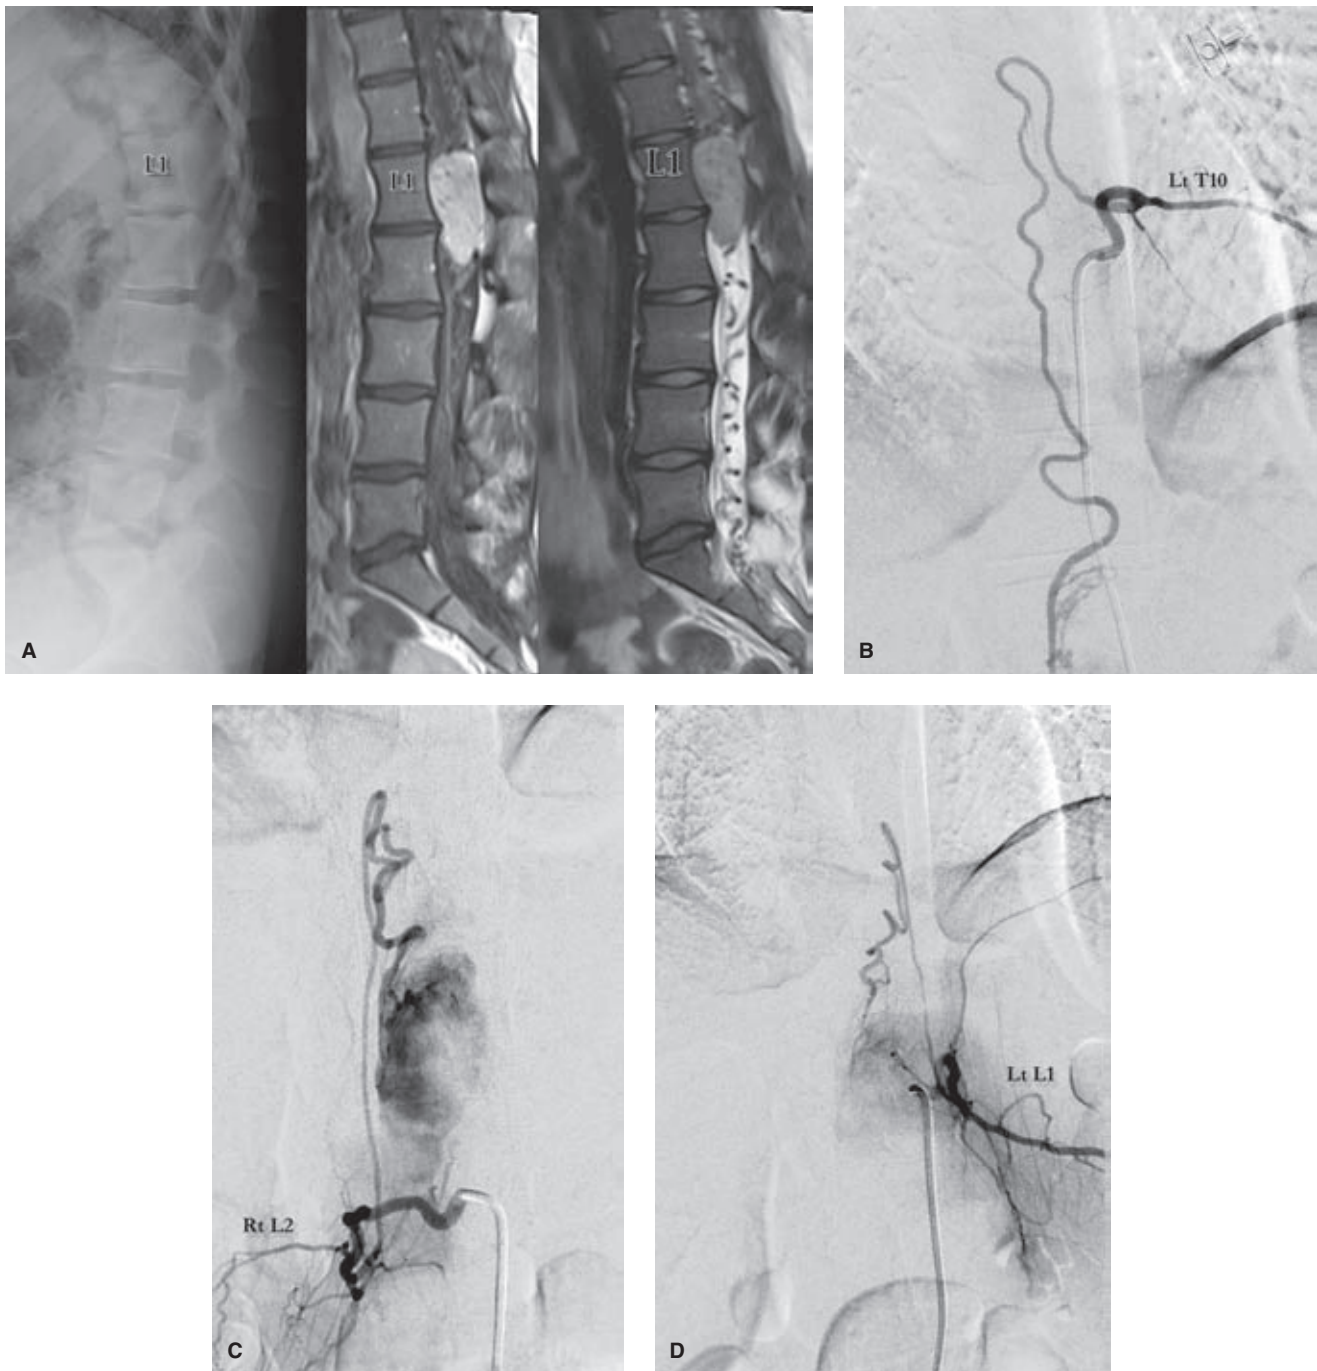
(A–D) Spinal hemangioblastoma presenting with bladder dysfunction and paraparesis. A young adult presented with precipitate decline of spinal function and back pain over a period of some weeks. Her MRI examination (A) showed an enhancing mass where the plain film demonstrated scalloping and remodeling of the posterior margin of L1. A profusion of large vessels in the canal raised the question of a spinal AVM, but the solid appearing nature of the lesion favored a hypervascular tumor. Preoperative angiography (images B–D) showed numerous enlarged arterial feeders from the anterior spinal artery (B) and posterior spinal arteries (D). The artery at right L2 was a little more difficult to analyze at first glance, but two factors classify it as an anterior spinal artery. Firstly, the ascending loop of the hairpin extends over three full vertebral body heights, very unusual for a posterior spinal artery. Secondly, careful review of the images showed that the inferior reaches of this vessel connected with those of the left T10 injection, forming a rete on the periphery of the tumor.
